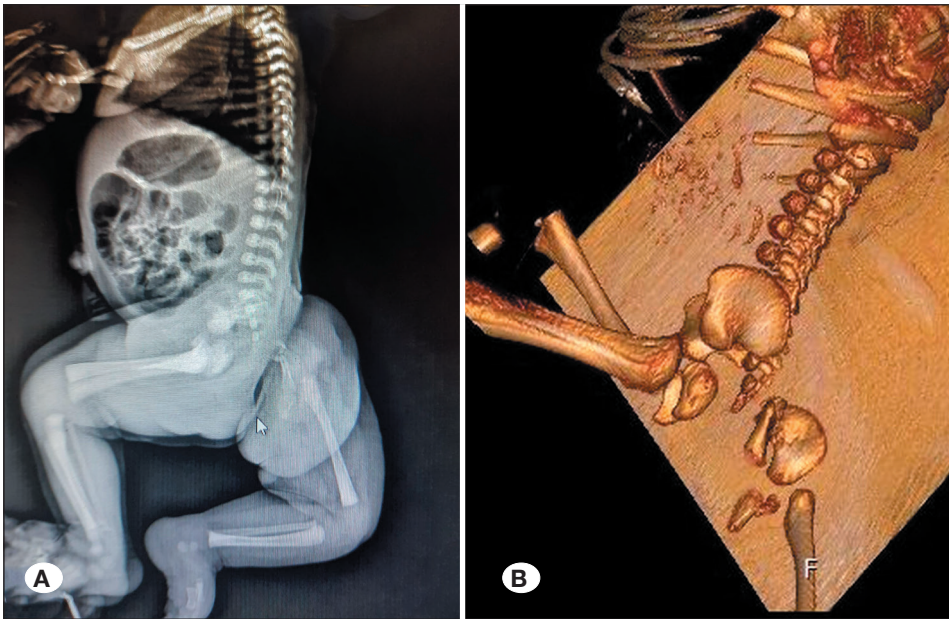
X-ray (A) and CT (B) lateral views of the pelvis, showing the additional ileum forming a partial acetabular joint with the head of the third femur and articulating with the sacral margin.
